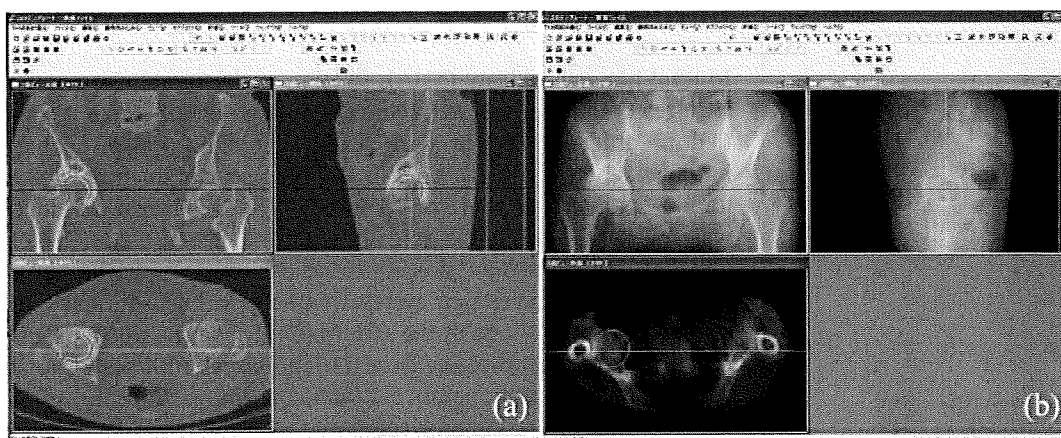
3D planning of the cup. (a) multi-planar (coronal, sagittal and axial) views of CT images. (b) Digitally reconstructed radiographs on the basis of the CT images. We can acquire these with any orthogonal coordinate system
